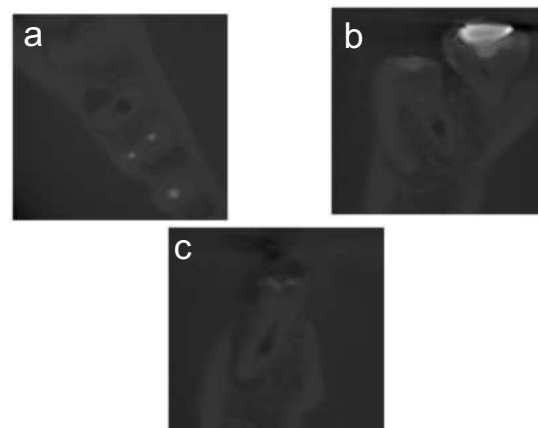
CBCT images axial section (a), sagittal section (b), coronal section (c)
